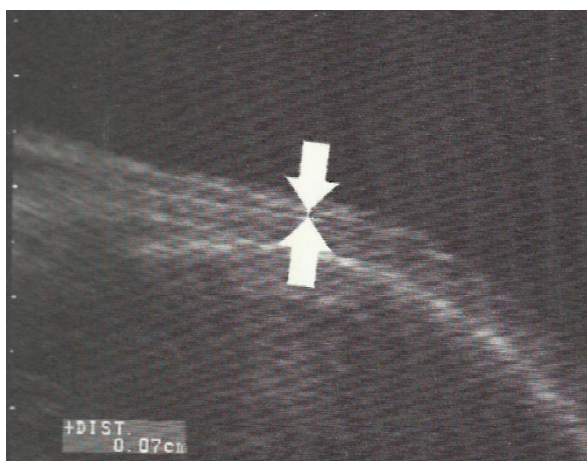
Longitudinal Sonogram showing an extremely thin LUS (0.7 mm)
